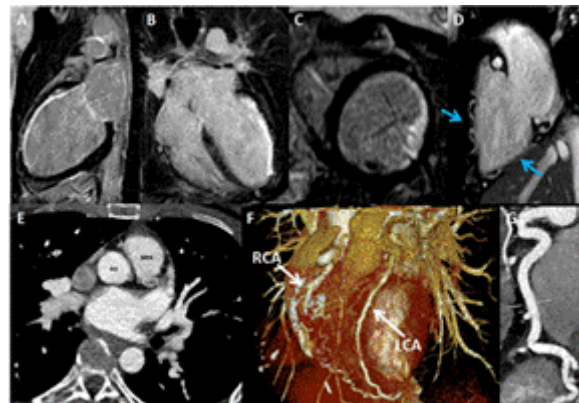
A-D: axial CT sequences, 2-chambers view. Figure B: LCA sequences, 4-chambers view. Figure C: LCA sequences, short axis view. LCA involves anterior papillary muscle. Figure D: 2-chambers view, collateral circulation (right blue arrow). Figure E: Axial multidetector CT angiogram shows the origin of the left coronary artery from the main pulmonary artery (MPA). Figure F: 3-D rendering of multidetector CT angiogram which shows the origin of the right coronary artery (RCA) and the left coronary artery (LCA). Figure G: CT image of a dilated RCA.
